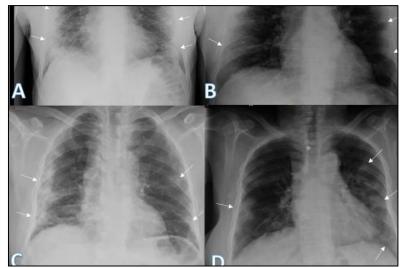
Chest X-ray findings monitoring COVID-19 disease course and severity. <sup>12</sup>
